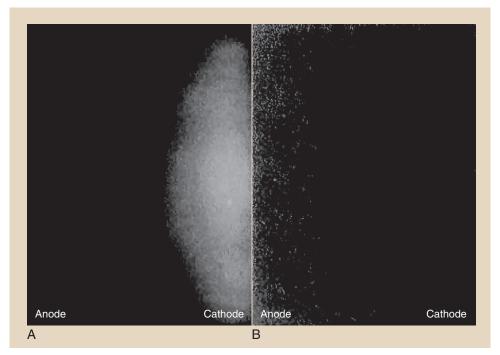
A, An image receptor exposed to a raw x-ray beam may show a heel-effect response. B, Flatfielding preprocessing can make the response uniform. (Courtesy Charles Willis, M.D. Anderson Cancer Center.)
